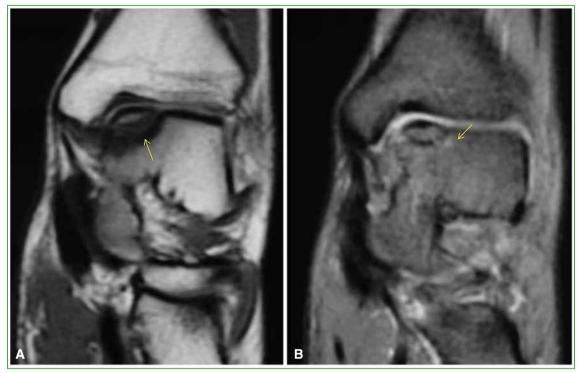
Frontal T1-weighted (A) and STIR (B) MRI sequences revealing an osteochondral lesion at the medial side of the talar dome associated with minimal bone edema.
